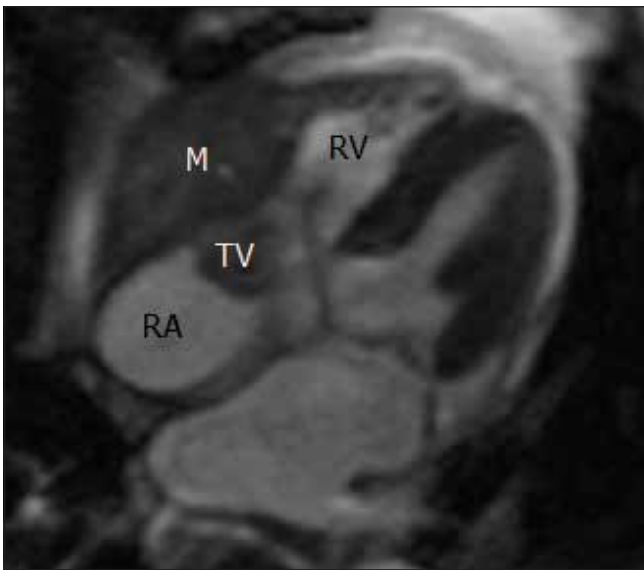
Cardiac magnetic resonance image demonstrating a large mass (M) involving the free surface of the right atrium (RA), right ventricle (RV) and tricuspid valve (TV).
